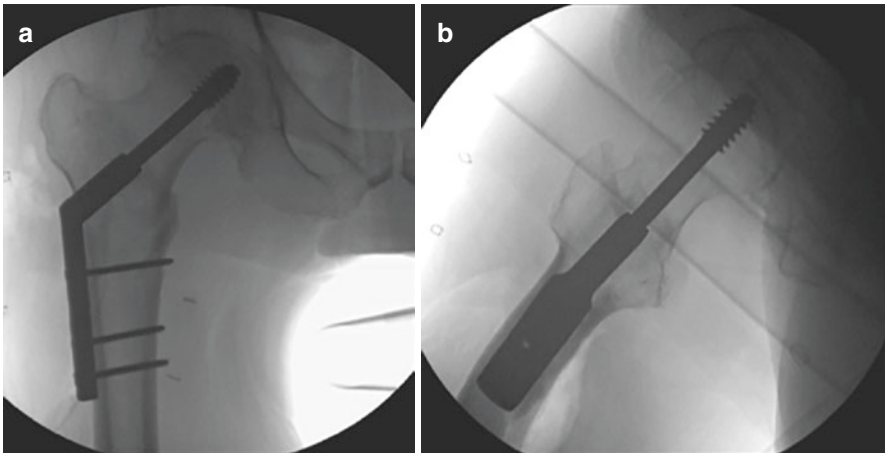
An 80-year-old male sustained a stable right intertrochanteric hip fracture. AP (a) and lateral (b) radiographs of a left hip demonstrate treatment with a sliding hip screw. The lag screw is placed central and deep
